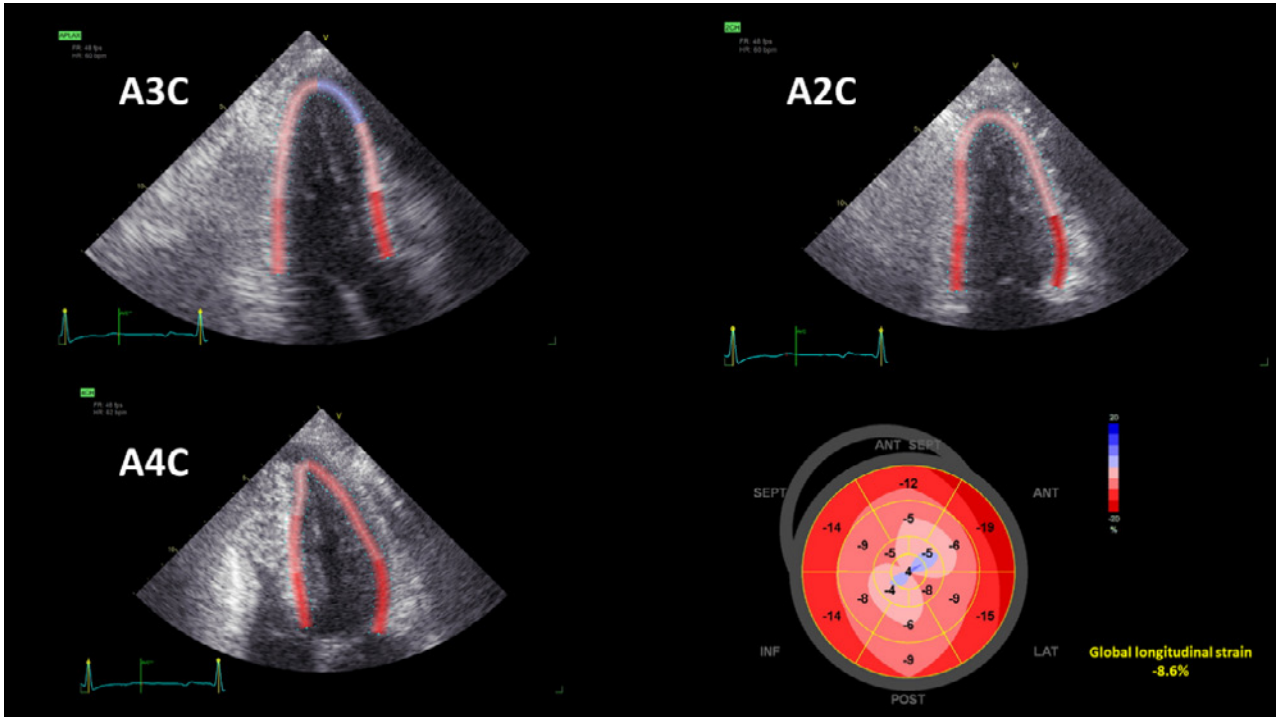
This figure shows 3 apical views with region of interesting on left ventricle myocardium for speckle tracking echocardiography. Bullseye mapping of longitudinal strain in right lower corner shows decreased strain in apical region in Case 1 (A3C = apical 3 chamber view; A4C = apical 4 chamber view; A2C = apical 2 chamber view; ANT SEPT = anteroseptal wall; SEPT = septal wall; INF = inferior wall; POST = posterior wall; LAT = lateral wall; ANT = anterior wall of LV).
